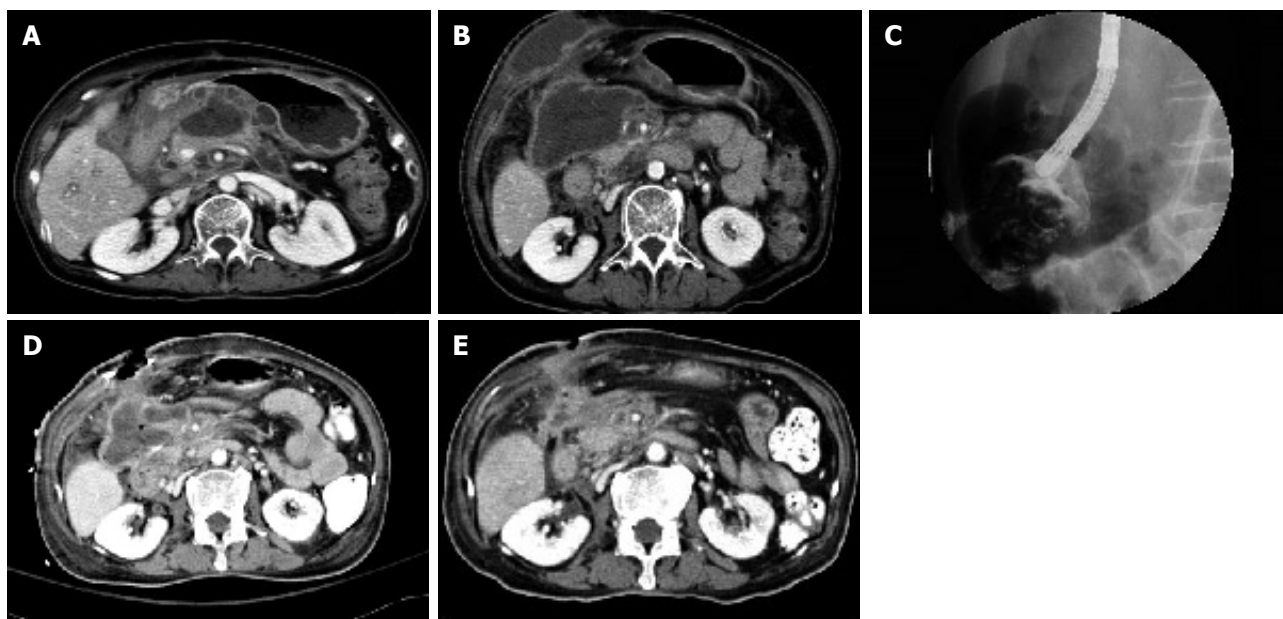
Multiple peripancreatic fluid collections on the body and head portions of the pancreas with a subcutaneous abscess on the right upper quadrant connected to these peripancreatic fluid collections (A, B), fluoroscopy and follow-up CT showing a frank pancreatocutaneous fistula and abdominal wall defects alongside the percutaneous route (C, D), follow-up CT showing nearly resolved infected peripancreatic necrosis, pancreatocutaneous fistula, and abdominal wall defect after endoscopic necrosectomy and repair of the fistula with fibrin glue (E).
